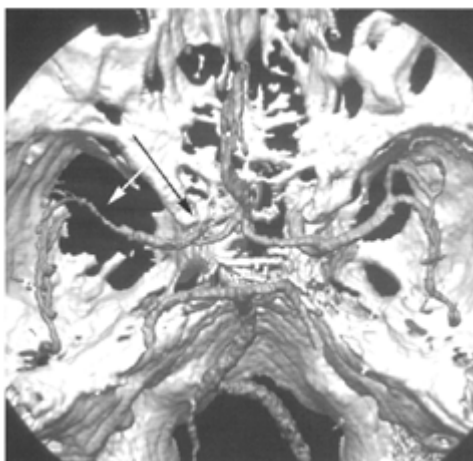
CT angiography in a patient with occlusions of the left internal carotid artery (black arrow, view from above) and of branches of the left middle cerebral artery (white arrow).
